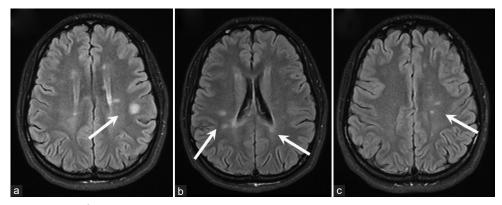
Multiple sections of axial T2/fluid-attenuated inversion recovery magnetic resonance imaging of the brain, showing multiple hyperintense lesions of varying sizes in the centrum semiovale (a and c), and the periventricular white matter (b)
